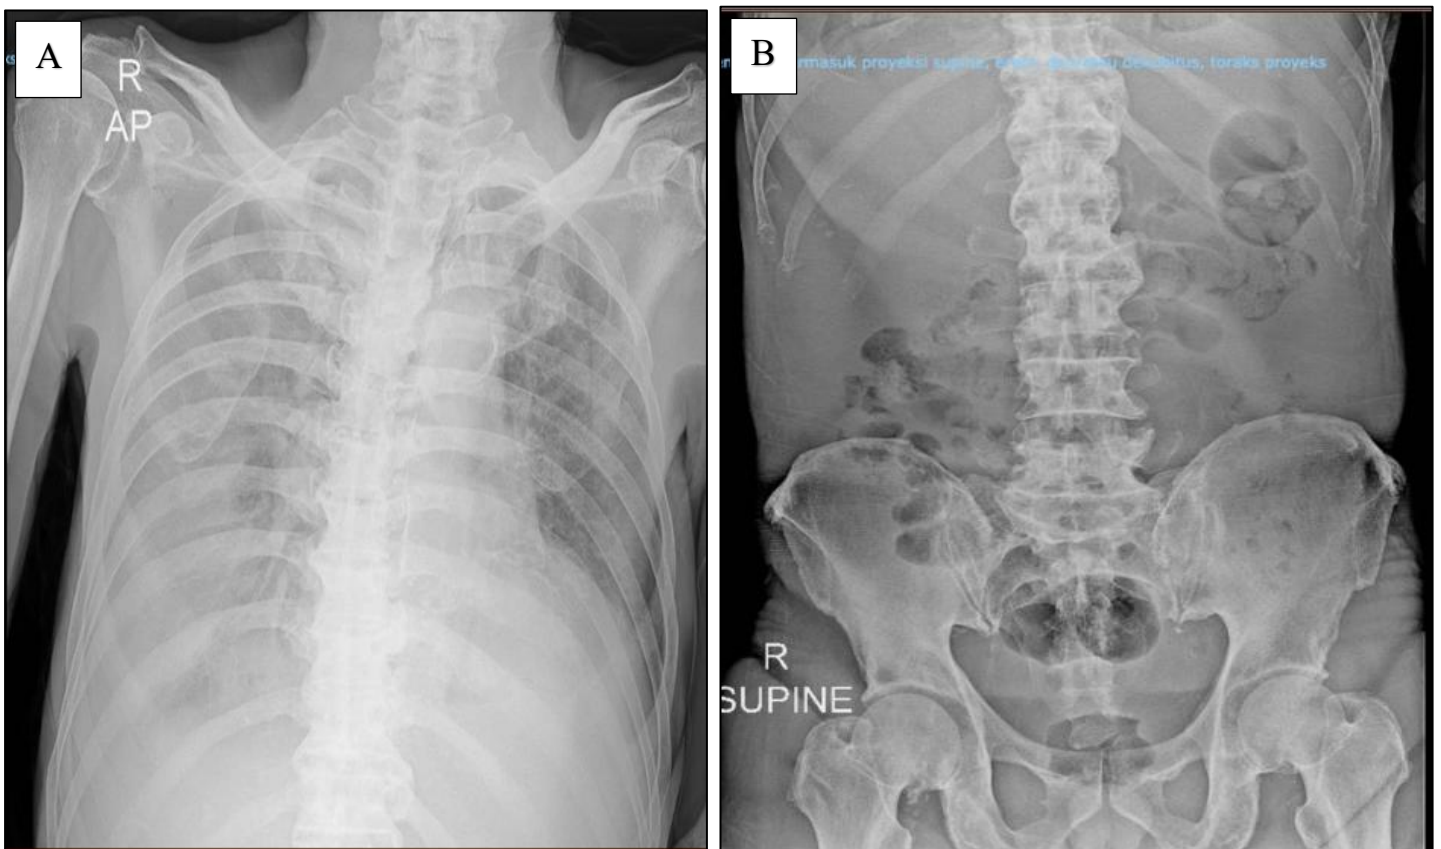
Radiological Findings; (A) Chest radiograph demonstrating cardiomegaly with bilateral pleural effusion, consistent with chronic congestive heart failure and reduced pulmonary reserve. (B) Abdominal radiograph (supine view) showing a non-specific bowel gas pattern, suggestive of inflammatory intra-abdominal pathology without clear evidence of mechanical obstruction.
